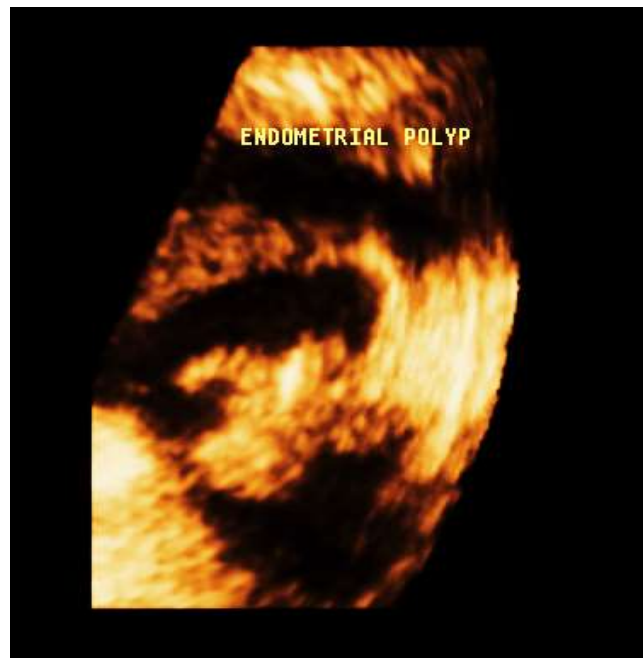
3D ultrasound surface rendering of large endometrial polyp
